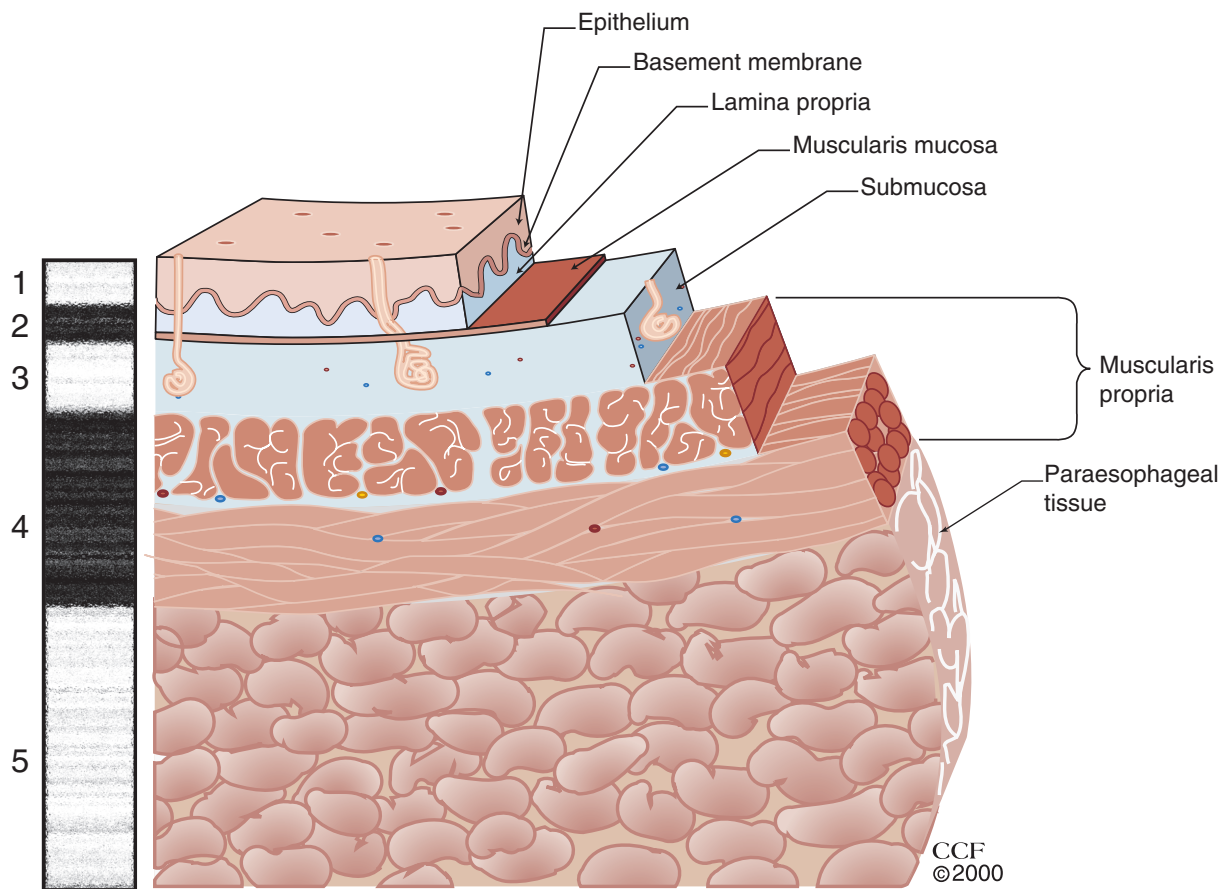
■ Esophageal wall is visualized as five alternating layers of differing echogenicity by esophageal ultrasound. The first (inner) layer is hyperechoic (*white*) and represents the superficial mucosa (epithelium and lamina propria). The second layer is hypoechoic (*black*) and represents the deep mucosa (muscularis mucosae). The third layer is hyperechoic and represents the submucosa. The fourth layer is hypoechoic and represents the muscularis propria. The fifth layer is hyperechoic and represents the paraesophageal tissue. The thickness of ultrasound layers does not equal the actual thickness of the anatomic layers.
